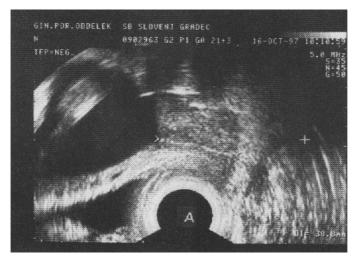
A. Measurement of cervical length by transvaginal sonography in a normal cervix.
